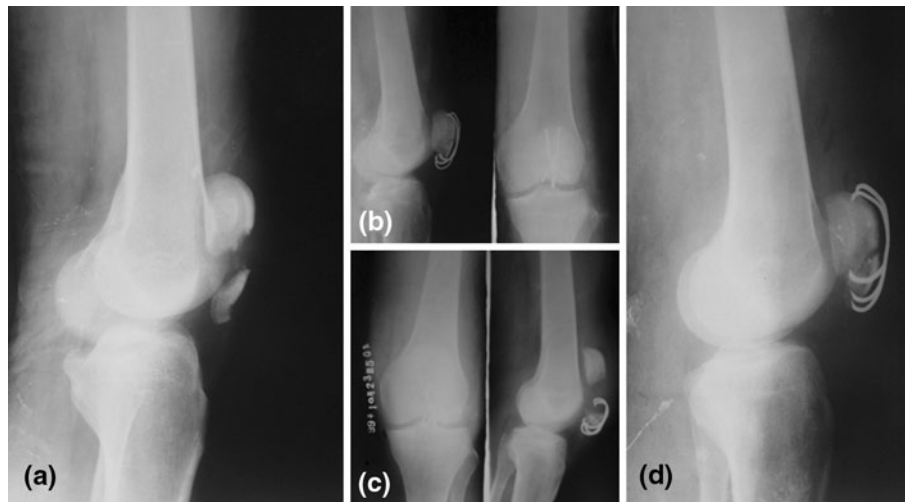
Lateral and anteroposterior radiographs (b) showing the comminuted and fragments (a) reduced and fixed by the Patellar Shape-Memory Fixator. The patient fell 4 weeks after operation and the PSMF weighed anchor fell loose (c). We repeated the procedure again (d) and obtained union at 8 weeks
